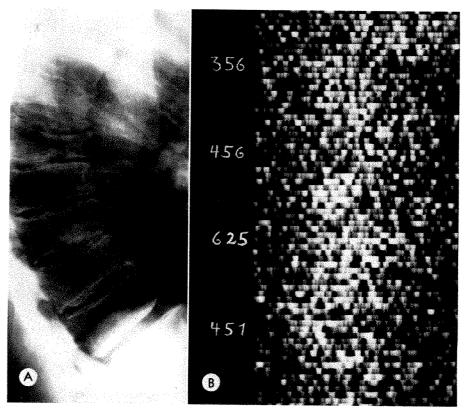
(A) Advanced osteoporosis of the thoracic spine in a 70 year old man. The alkaline phosphatase was elevated to 27 King Armstrong units. (B) Increased radioactivity in the lower thoracic spine. The autopsy findings 1 month later confirmed the scintigraphic diagnosis of vertebral metastases of an unknown bronchogenic carcinoma. (The numbers indicate counts per minute.)
